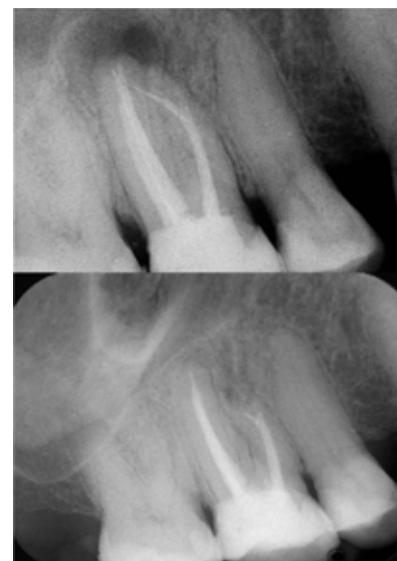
Iatrogenically fractured and displaced instrument over the apex, which was orthograde and no longer removable. Bottom: Two-year follow-up (periapical X-ray 16) with almost complete osseous regeneration (root end filling with Biodentine (Septodont, Saint-Maur-des-Fossés, France).
